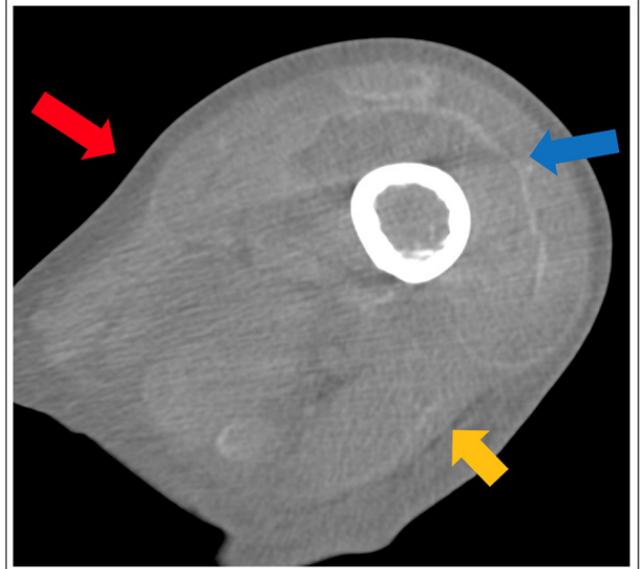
Axial non-contrast CT images of the mid-distal femur demonstrate a thin layer of subcutaneous fat (red arrow). There is some edema within the subcutaneous fat which has a more hyperdense and strand-like appearance (orange arrow). The muscles are somewhat hypodense as evident by the prominent appearance of the myotendinous junction (blue arrow). The hypodense appearance of the muscles is due to the gelatinous deposition within the muscles. Gelatinous material has a higher water content which gives the muscles a hypodense appearance relative to the tendon. The bone marrow signal is nearly equal to that of the muscles suggesting further gelatinous deposition in the bone marrow. The bone cortex maintains its normal density.
